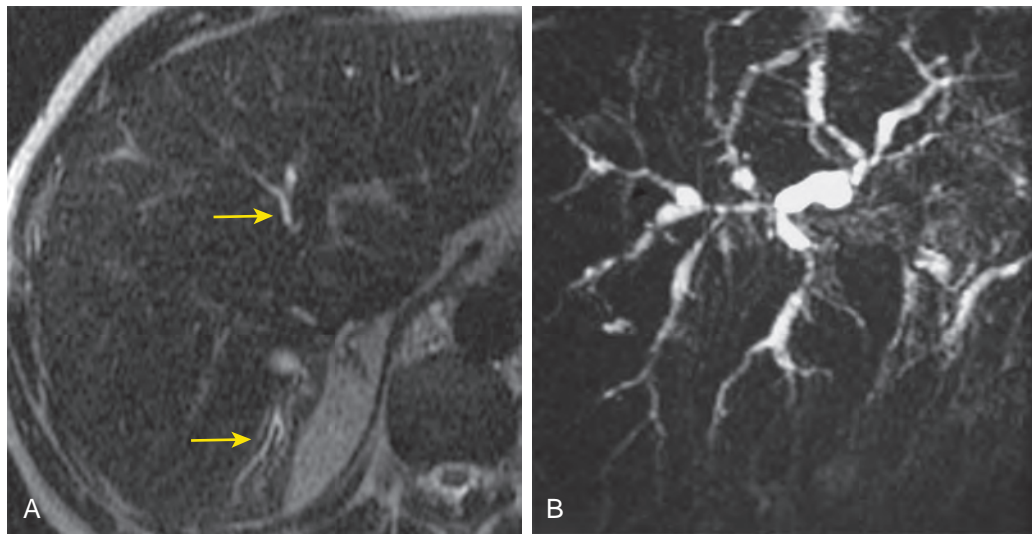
Sclerosing cholangitis. Axial T2-weighted MR images shows focal dilation of intrahepatic bile ducts in two areas (arrows). B. MRCP image shows multifocal strictures and irregularity of the intrahepatic bile ducts.
